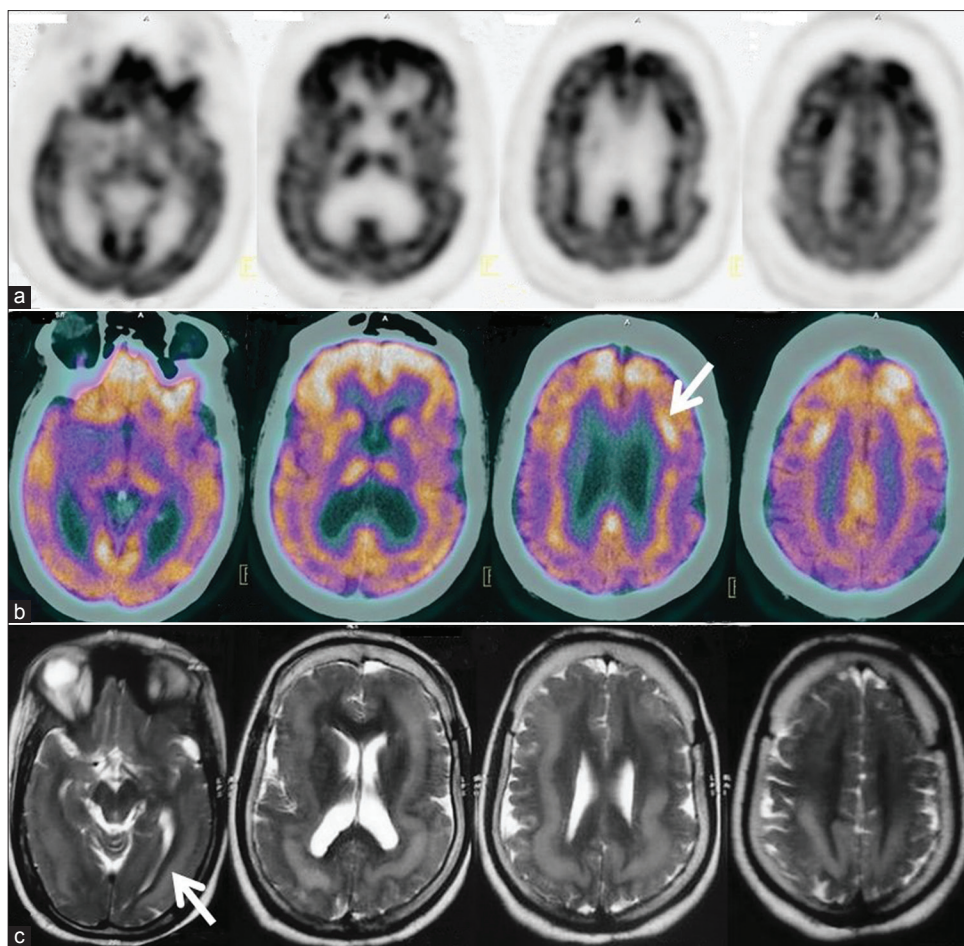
The transaxial PET images (a) revealed abnormal tracer accumulation in the subcortical region extending across the frontal, parietal, temporal and occipital lobes. The fused transaxial PET/CT images (b) clearly delineated this uptake to a bilateral symmetrical band located between the ventricular wall and cortical mantle involving the frontal, parietal, temporal and occipital lobes in both the hemispheres. (c) MRI images of the patient clearly demonstrated the thick isointense subcortical band (arrow) suggestive of DBH
